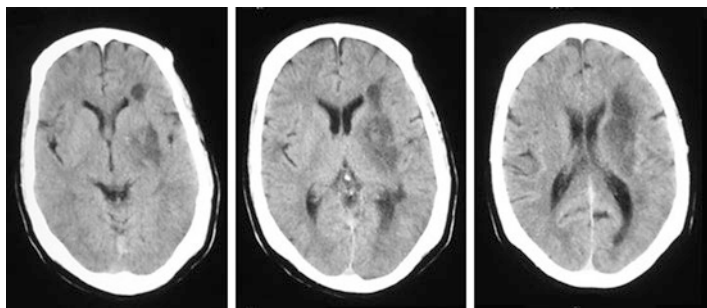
Non-contrast CT scan of the same patient as in Fig. 3.26 showing the now obvious left basal ganglia infarct (low density) about 1 week after the onset of symptoms
